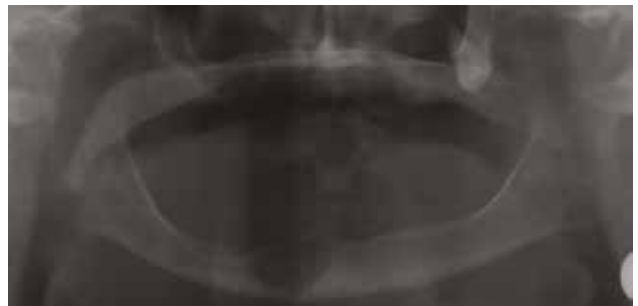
Preoperative radiograph of a well-defined radiolucent lesion which was causing insufficient distance between the lesion and inferior border of the anterior region of mandible.
